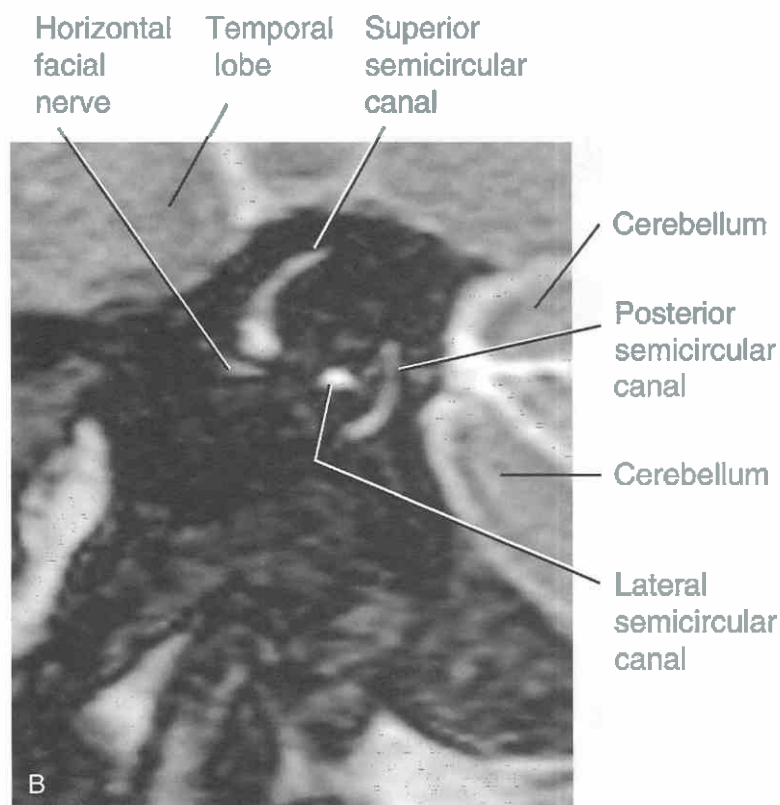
Sagittal views, normal anatomy. *A*, Sagittal CT reconstruction made at the level of the epitympanic space. The most medial portion of the mandibular condyle and the mandibular fossa are seen. The styloid process and the mastoid air cells are visible. The head of the malleus and the long process of the incus are visible in the epitympanic space. The thin wall of the epitympanic space, the semicircular canals, and a portion of the facial nerve canal in the middle ear are visible. *B*, Sagittal MR section.
